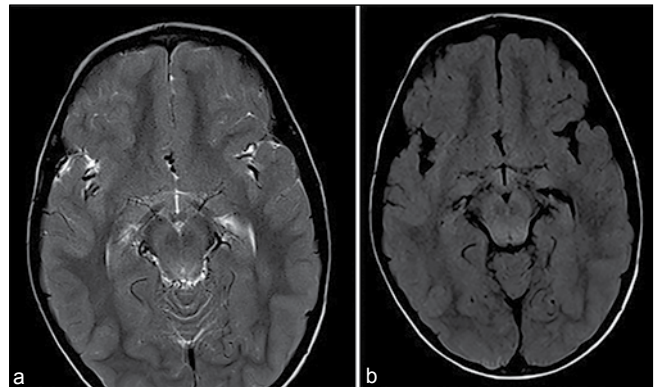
Axial T2/FLAIR MRI images reveal hyperintense lesions involving most of the midbrain, hypothalami, hippocampi (2a and b)
